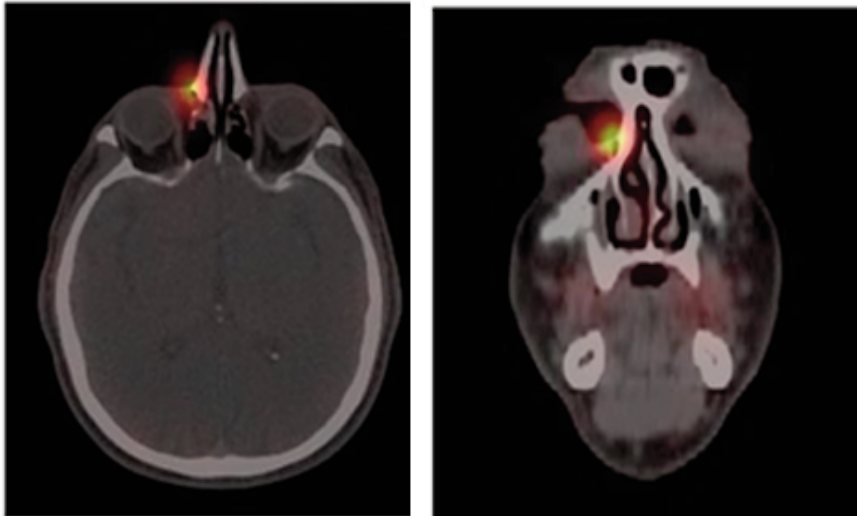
Zoom axial CT and fused SPECT-CT images show focal increase uptake in the right nasolacrimal sac/duct. It is noted that mucosal thickening at right ethmoidal sinus is likely due to sinonasal disease that further decreases the flow in the nasolacrimal ducts and thus increases the exposure to ^{131}I odine, which is secreted through the lacrimal system.
